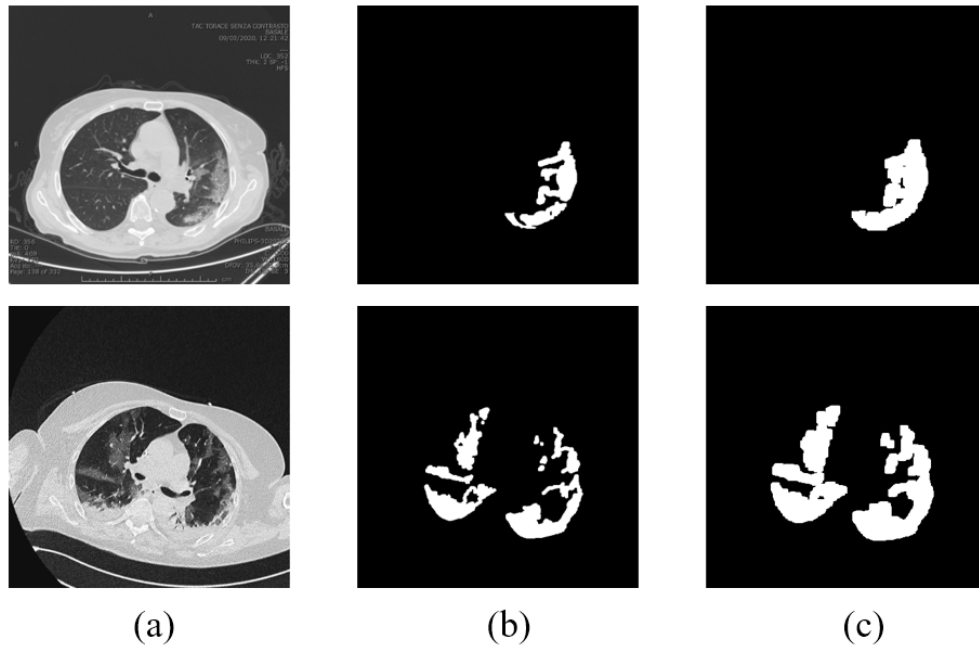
Segmentation Outcomes on Non-COVID-19 CT Images. (a) Original Image. (b) CAED [105]. (c) Proposed OU-Net with MGWO.
